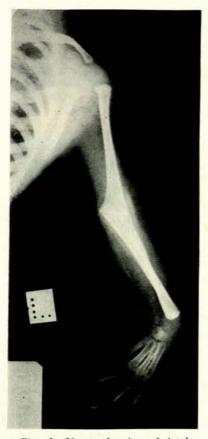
X-ray showing skeletal abnormalities of left upper limb (case 1).
